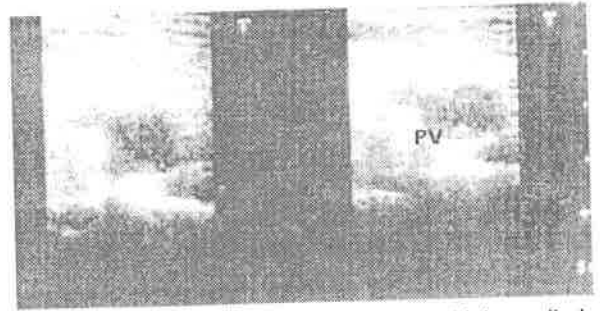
Doppler ultrasound of a patient with lower limb DVT showing lack of compressibility of popliteal vein and thrombus in the popliteal vein (PV).
